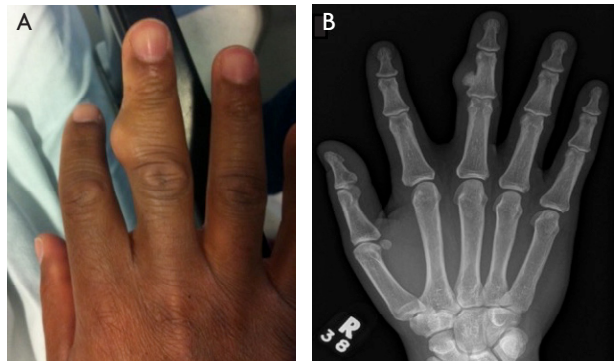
A photograph (A) and radiograph (B) of the right middle finger associated with a recurrent lump.
